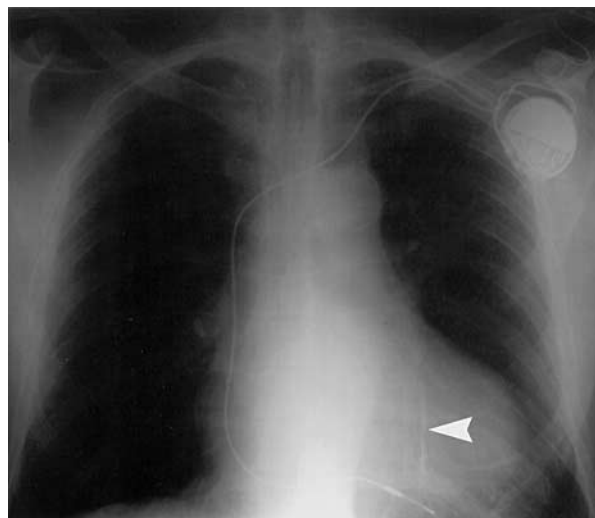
Chest X-ray following pacing demonstrates the linear metallic fragment (white arrowhead)
